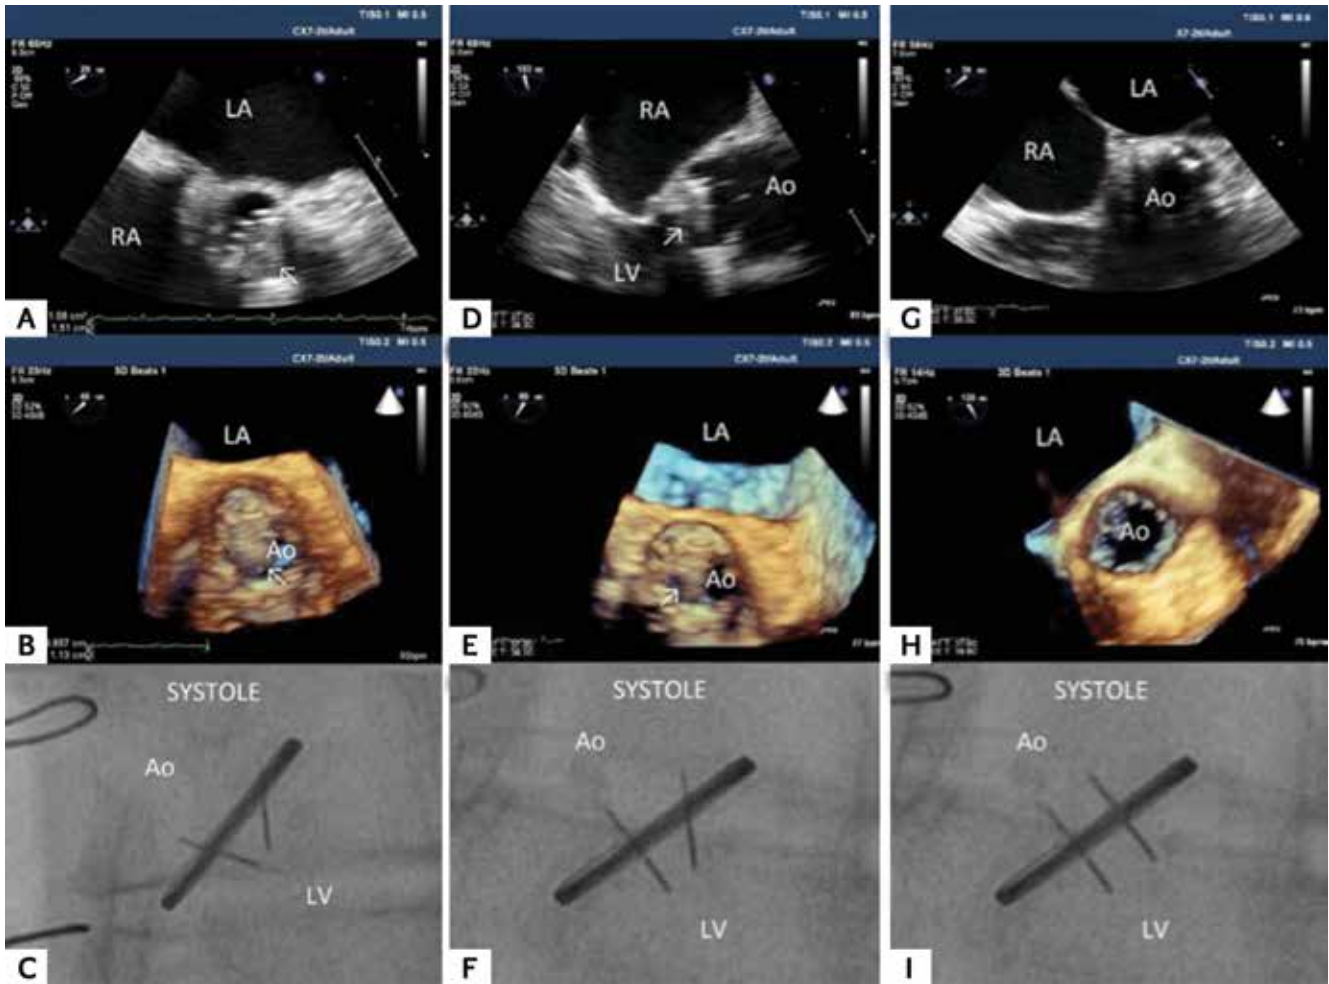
(A) Two-dimensional transesophageal echocardiography (2D TEE) and (B) real-time 3-dimensional transesophageal echocardiography (RT-3D TEE) showing an obstructive thrombus on the aortic mechanical prosthesis. (C) Left anterior oblique cranial fluoroscopy provided a tangential view showing one leaflet fixed in closed position and the other semiopen during systole. (D) 2D TEE and (E) RT-3D TEE could not reveal any progression of thrombolysis or resolution of leaflet restriction; however, (F) fluoroscopy revealed one leaflet normally opened and the other semiopen during systole after 25 mg tPA infusion. (G) 2D TEE and (H) RT-3D TEE showed normally functioning mechanical aortic valve with resolution of the thrombus burden and (I) restriction of leaflets was nearly completely resolved on fluoroscopy after totally 50 mg of tPA infusion. RA: Right Atrium, LV: Left Ventricle, LA: Left Atrium, Ao: Aorta, arrows show thrombus on the mechanical aortic prosthetic valve.
